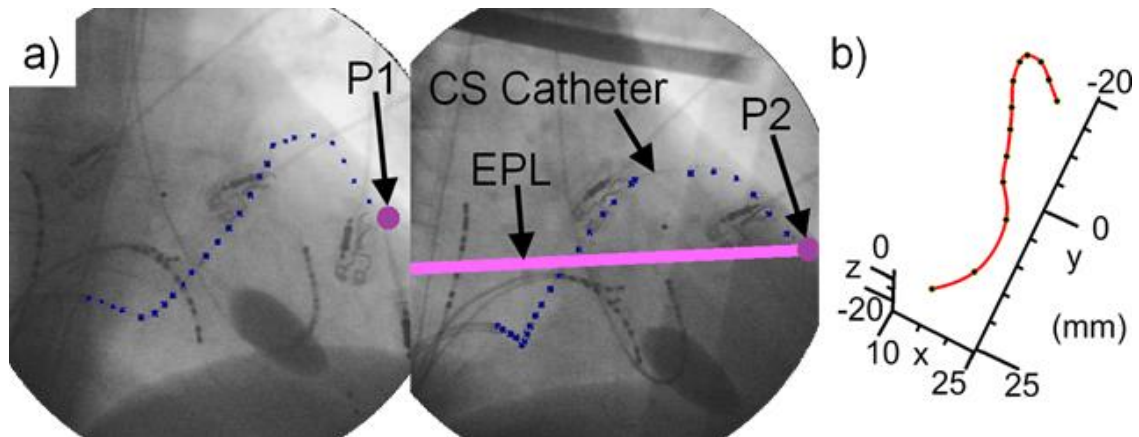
a) AP (*left*) and LAO 30° (*right*) X-ray views of the heart gated at end-diastole and end-expiration. Points along the CS catheter are selected in both images (*blue dots*). A point from the left image (*P1*) generates an epipolar line in the right image (*EPL*); its corresponding point lies at an intersection of EPL and the catheter (*P2*). b) 3D Spline reconstruction of the catheter.
